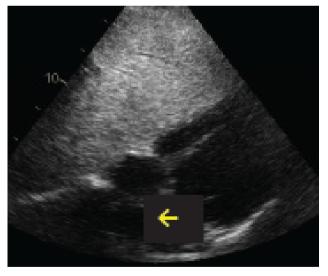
Transthoracic echocardiography showing the subcostal view. Note that IAS (yellow arrow) is almost horizontal, perpendicular to the ultrasound beam.
